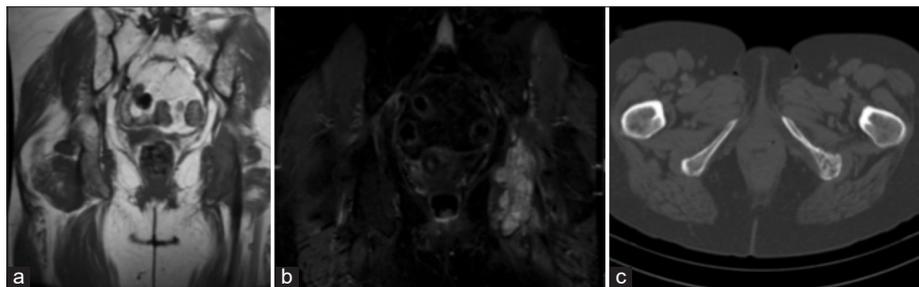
Ewing's sarcoma. Coronal T1 (a), short-tau inversion recovery (b), and axial computed tomography (c) showing Ewing's sarcoma of the left ischium.
